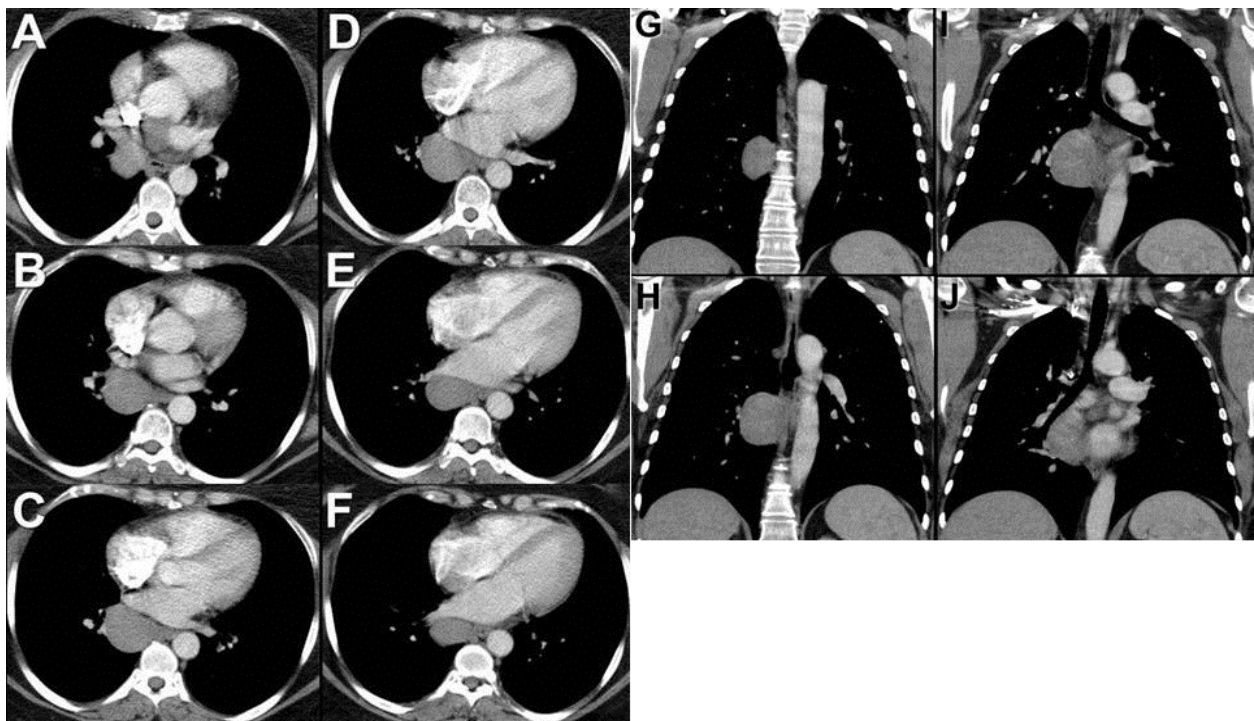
Axial (A-F) and coronal (G-J) enhanced thoracic CT.
